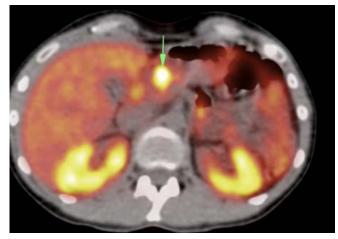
PET-CT with 68Ga shows that the tumour from Figure 3 exhibits overexpression of somatostatin receptors.
